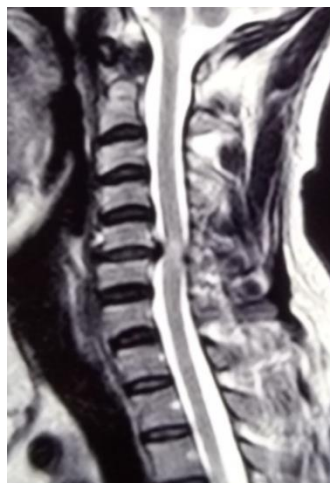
Sagittal section of MRI cervical spine showing disc level compression at C5-C6 level
